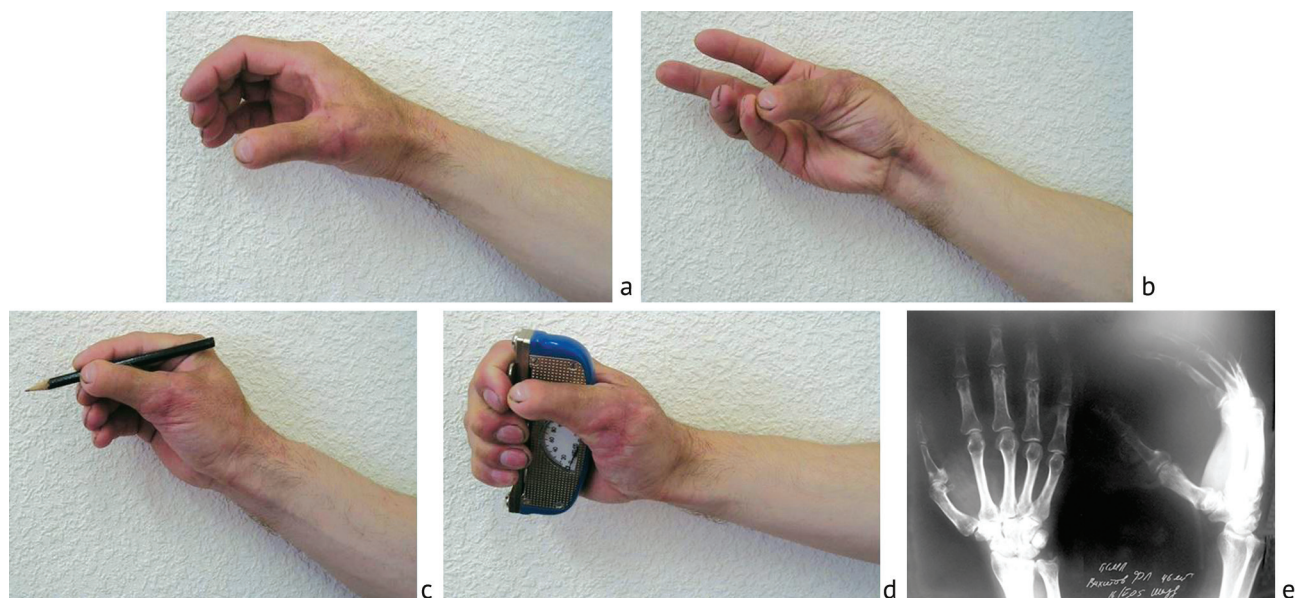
Appearance (a–d) and radiograph of the right hand (e) at a long term
